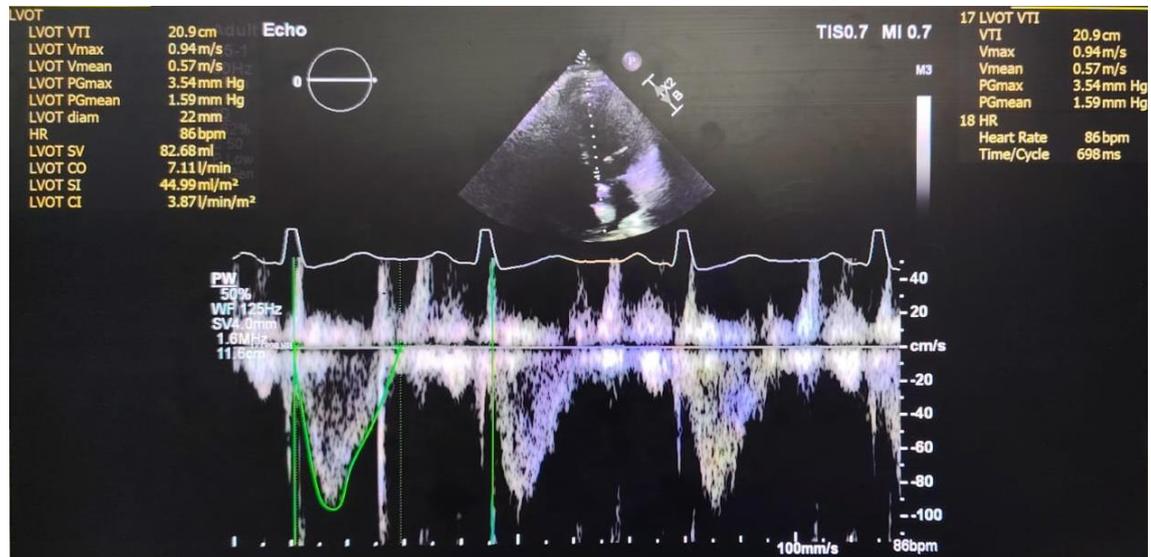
Measurement of LVOT VTI from echocardiography.
